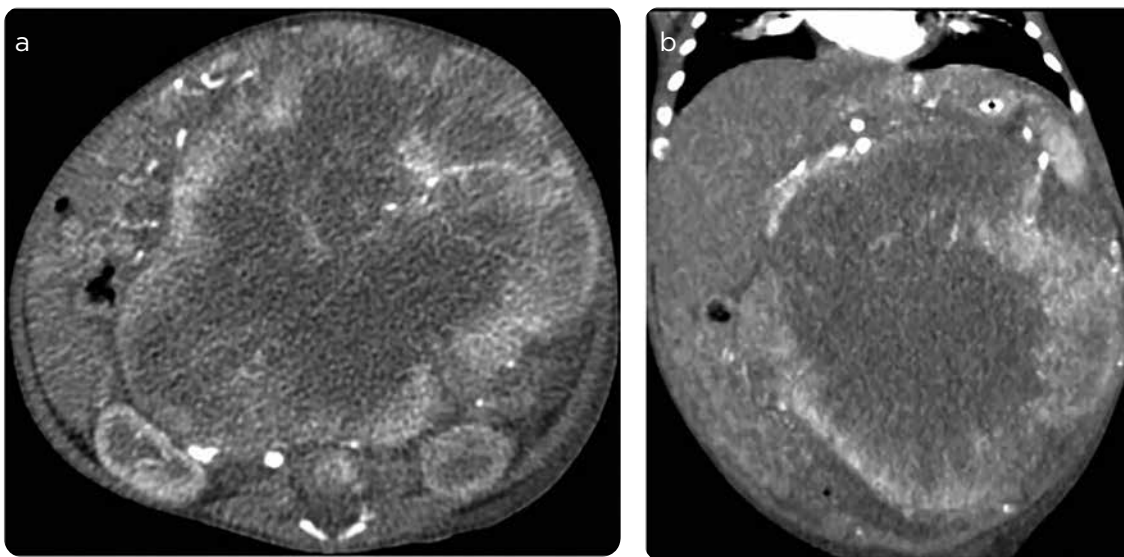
CT scan of abdomen with contrast medium, control one month after biopsy. a) Axial. b) Coronal. Mass with peripheral enhancement after administration of the contrast medium, with significant increase in size that occupies almost the entire abdomen, areas of low signal inside without enhancement of the contrast medium by necrosis, displacement of solid organs towards the abdominal periphery.
